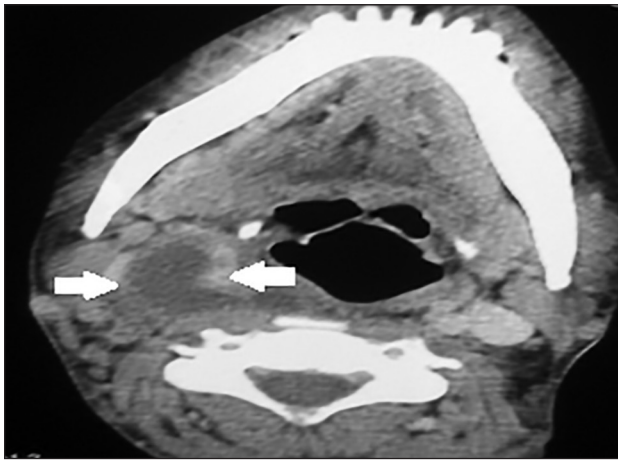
CT neck: Hypodense collection in the neck (arrows)
